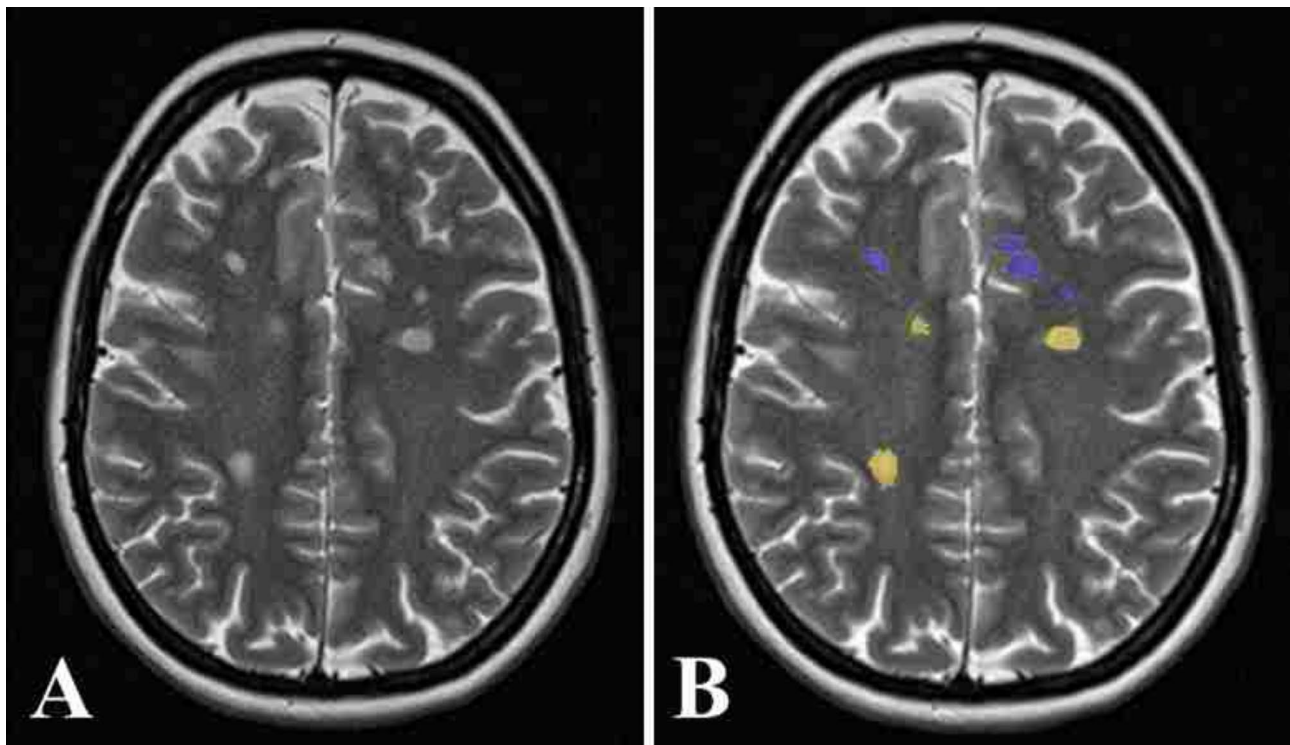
The segmented active (Yellow) and non-active (Blue) plaques on T2-weighted MRI images using Slicer
